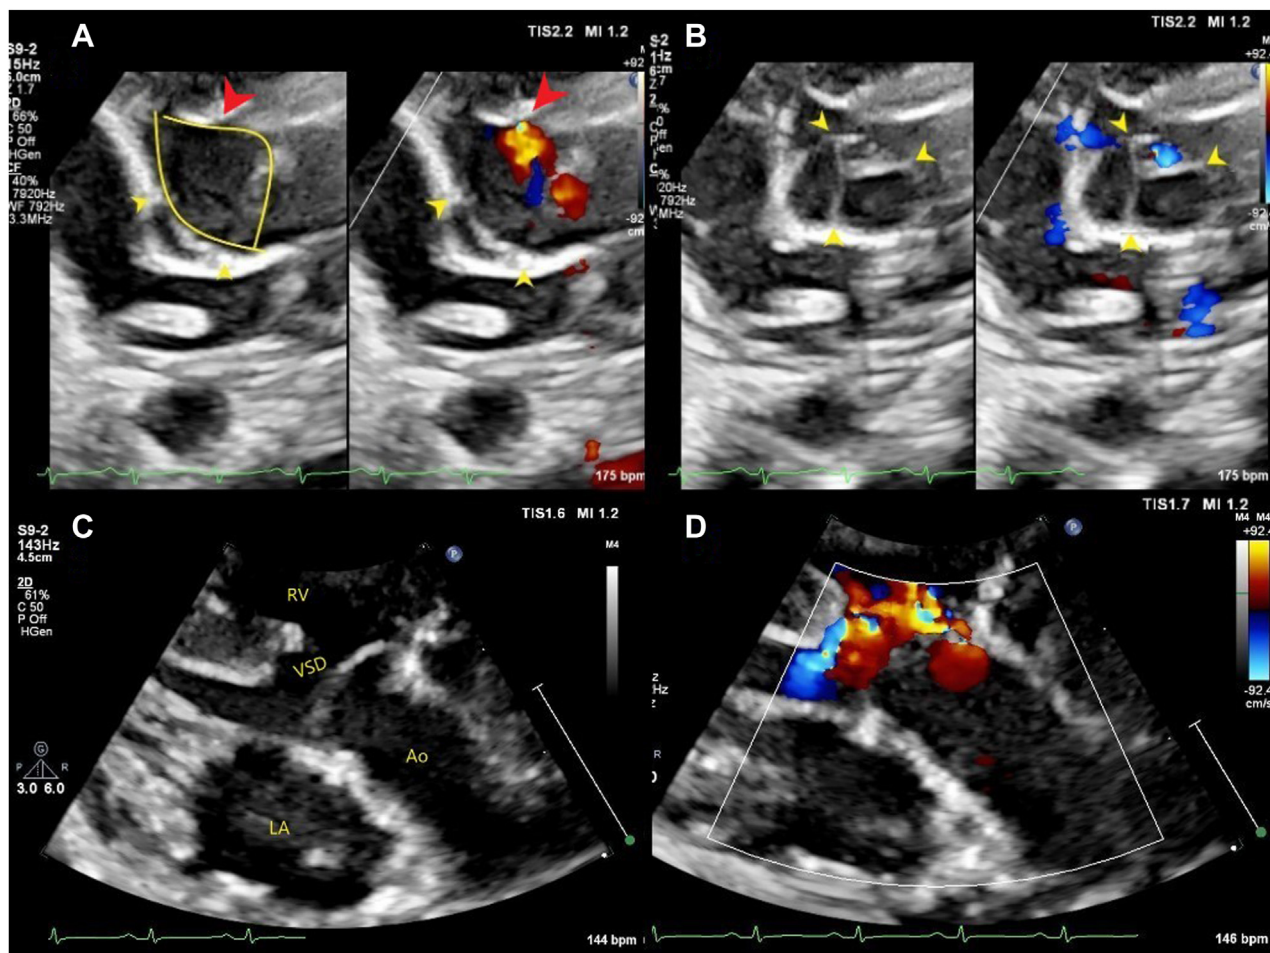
Dysplastic aortic valve. (A) Two-dimensional TTE, parasternal short-axis (PSAX) en face view of the aortic valve, without (*left*) and with (*right*) color-flow Doppler in systole, demonstrates a dysplastic, bicuspid valve with fusion of the right and left coronary cusps (*red arrows*). The two other *yellow arrows* demonstrate the right and noncoronary commissures. (B) Two-dimensional TTE, PSAX en face view of the aortic valve, without (*left*) and with (*right*) color-flow Doppler in diastole, demonstrates 3 separate commissures (*yellow arrows*). (C) Two-dimensional TTE, parasternal long-axis (PLAX) view of the aortic valve in diastole, demonstrates the billowing of the aortic valve leaflets as they prolapse backward into the VSD. (D) Two-dimensional TTE PLAX view with color-flow Doppler of the aortic valve in diastole demonstrates moderate to severe AR. Ao, Aorta; LA, left atrium.
